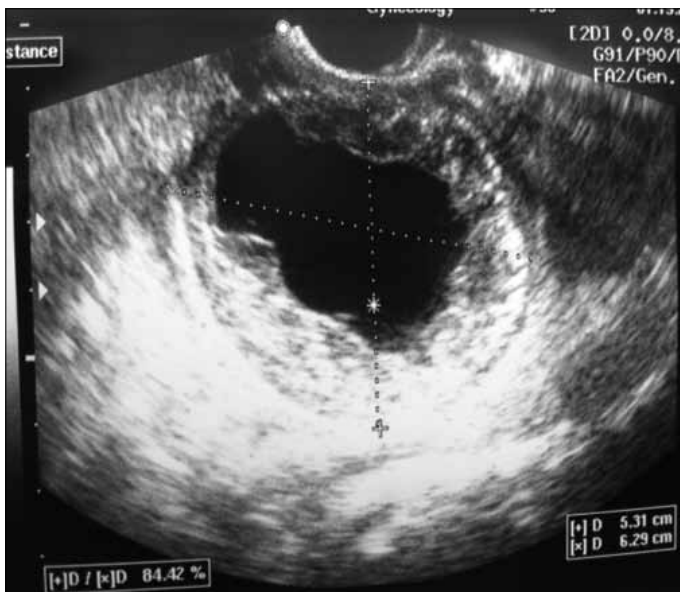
The sonographic view of the right adnexal mass.
